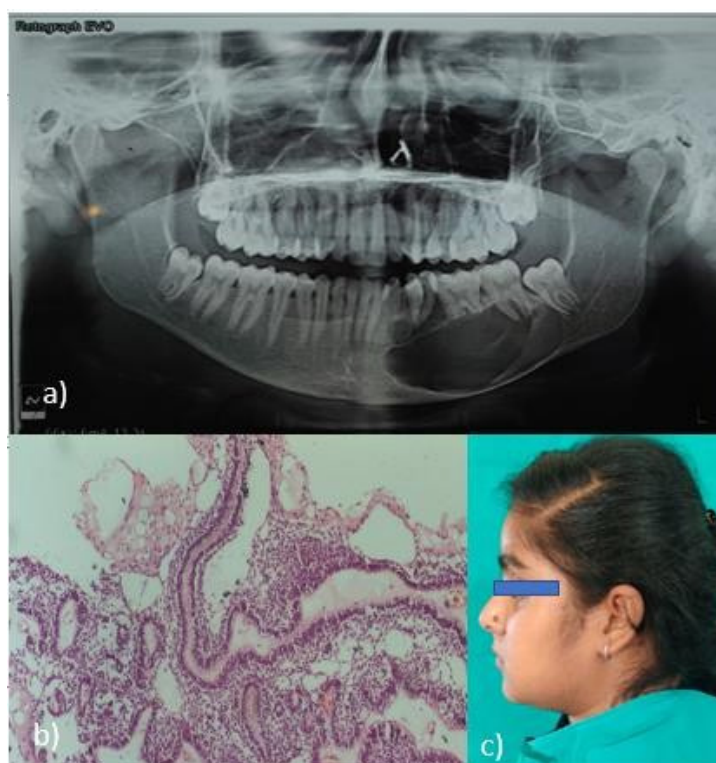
a) Orthopantomograph shows unilocular radiolucency with sclerotic borders from 33 to mesial root of 38 region.
